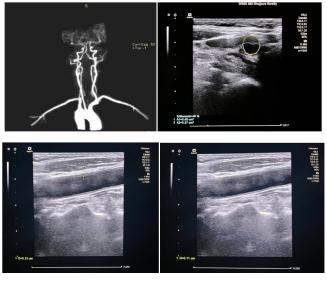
Case 3- MR angio neck vessels revealing mild diffuse intimal thickening of bilateral common carotid arteries and focal short segment mild to moderate (35–40%) narrowing of right internal carotid artery in its proximal part just after origin and usg doppler neck vessel revealing mild diffuse intimal thickening of bilateral common carotid arteries, focal short segment 40% narrowing of proximal right internal carotid artery
